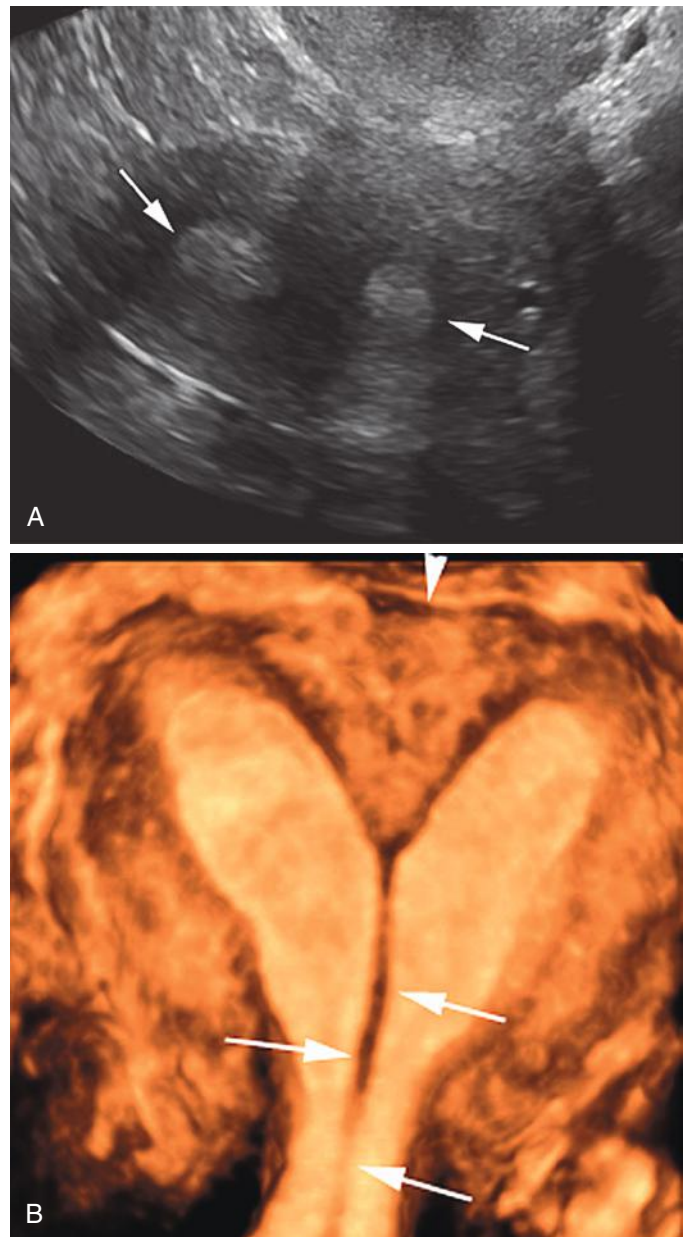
Septate uterus. A, Gray-scale axial transvaginal sonogram of the uterus shows a divided echogenic endometrial cavity (arrows). B, Three-dimensional rendered coronal image clearly demonstrates a complete thin uterine septum (arrows) dividing the endometrial cavity, extending from the fundus inferiorly into the cervix, below the level of the internal os. Note that the outer serosal contour of the uterine fundus remains smooth, without indentation (arrowhead).
